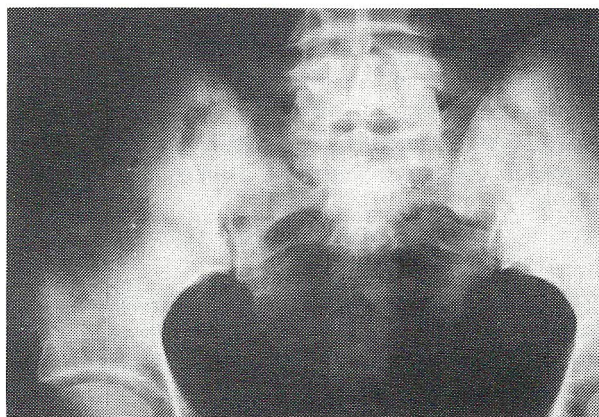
X-ray film of the lumbosacral spine and pelvic bones. Spots of homogenisation and rarefaction characteristic for secondary manifestations of the basic malignant process.
